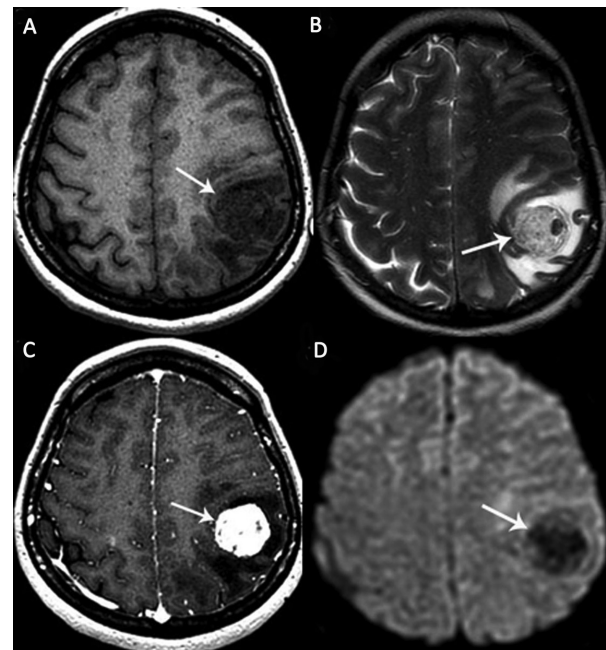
A left parietal lobe cavernous malformation (CM) in a 41-year-old female patient with a headache. (A) Axial T1-weighted magnetic resonance (MR) image shows a hypointense heterogeneous cortical mass. (B) Axial T2-weighted MR image shows a “berrylike” mass with heterogeneous hypointense and hyperintense signals (arrow). There is a prominent perifocal edema. (C) The mass shows intense heterogeneous enhancement on contrast-enhanced T1-weighted MR image (arrow). (D) The mass is hypointense on diffusion-weighted imaging (DWI) without any restricted diffusion (arrow).
